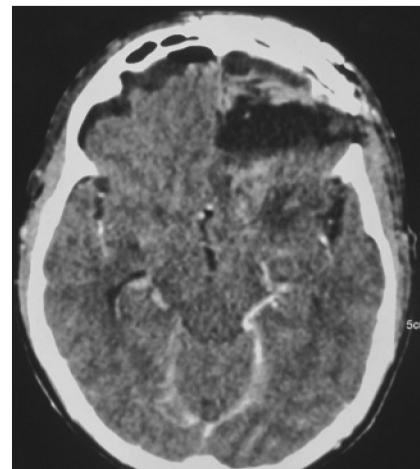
Postoperative CT scan showing complete tumor excision
